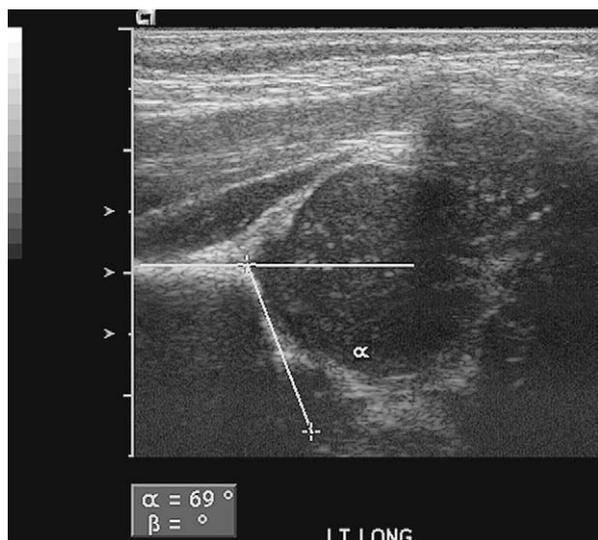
A normal hip on ultrasound.
